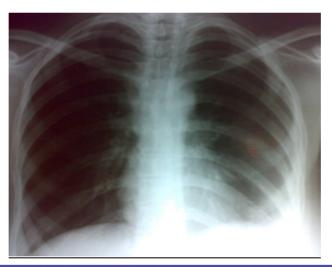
Chest X-Ray after two weeks of treatment with antituberclosis drugs. It shows clearance of the shadows and mediastinal lymphadenopathy.
